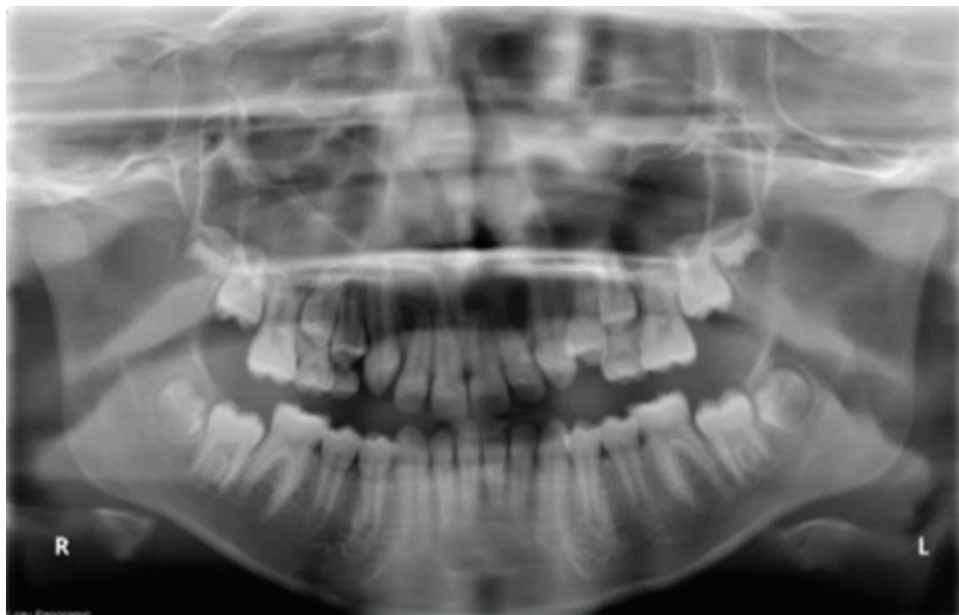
Radiographic image.
